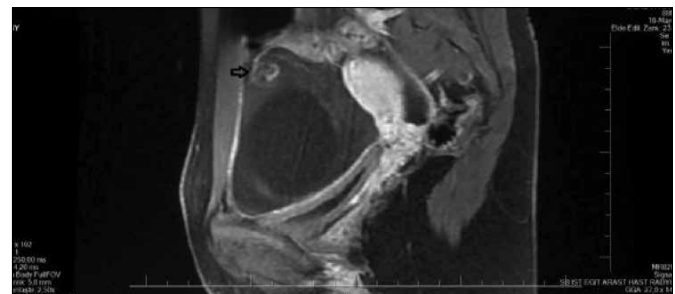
T1-weighted sagittal MR image. Torsion/rotation area in dilated tuba (arrow; mass image which is formed from concentric circles, whorl sign)
